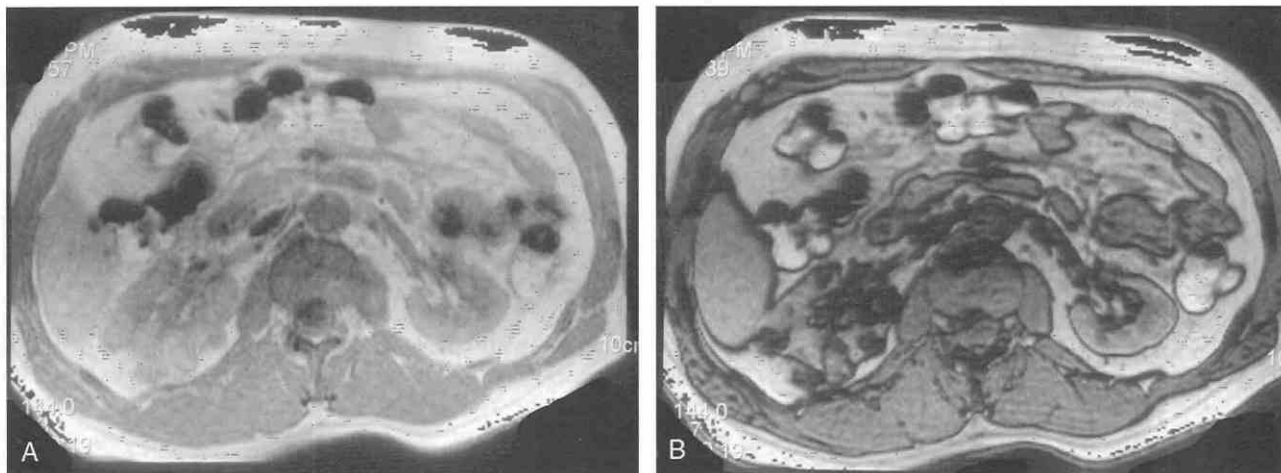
Multiple angiomyolipoma. In- and out-of-phase MR image in axial projection (*A*) demonstrates multiple small lesions in the right kidney that have a slightly higher signal compared with the surrounding renal parenchyma. *B*, Out-of-phase pulse sequence demonstrates a significant drop in the signal of these lesions, consistent with the presence of fat. Post-gadolinium enhancement images (not shown) did not reveal any enhancement.
